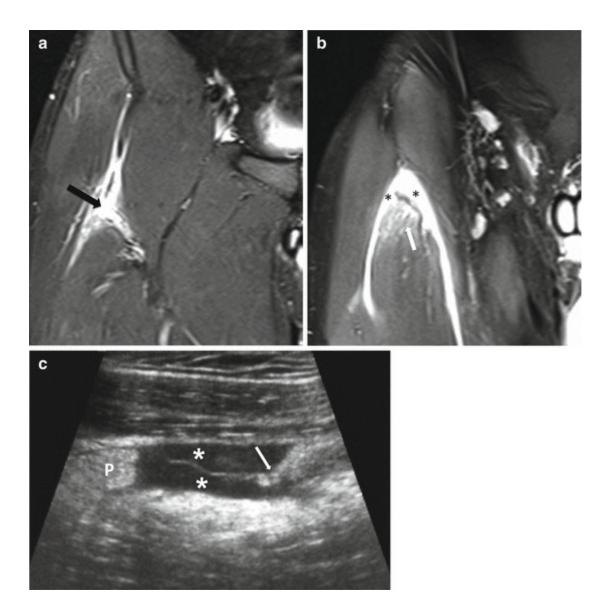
A 31-year-old soccer player with complete rupture of the conjoint tendon of the right rectus femoris. (a, b) Coronal fat-suppressed T2-weighted MRI. (a) Full thickness discontinuity of the conjoint tendon of the rectus femoris (*arrow*). (b) Feathery edema within the upper pole of the rectus femoris in keeping with interstitial edema and hemorrhage (*arrow*). Fluid collection surrounding the upper pole of the rectus femoris is noted (*asterisks*). (c) Sagittal ultrasound image shows complete tear of the proximal tendon (*P*). The distal stump is pointed with a *white arrow*. The fluid collection appears anechoic (*asterisks*)
